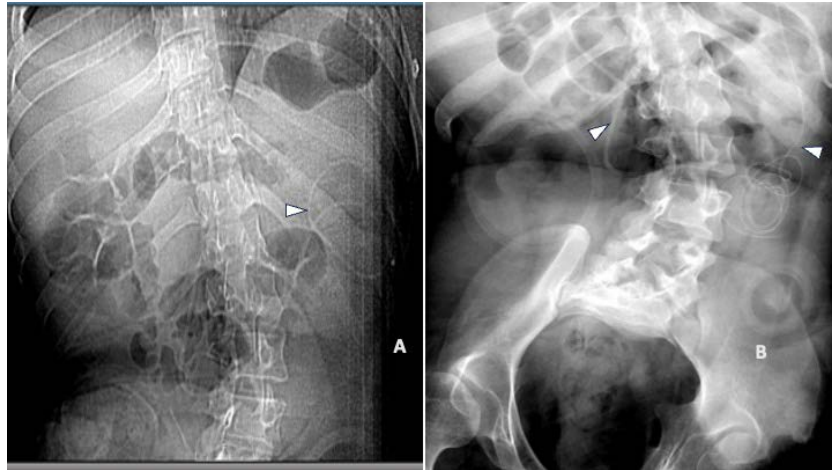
Comparison of chest CTA scout topogram (A) with prior ventriculoperitoneal shunt series abdominal radiograph (B) demonstrating notable absence of the recently placed small caliber distal left VP shunt catheter.
